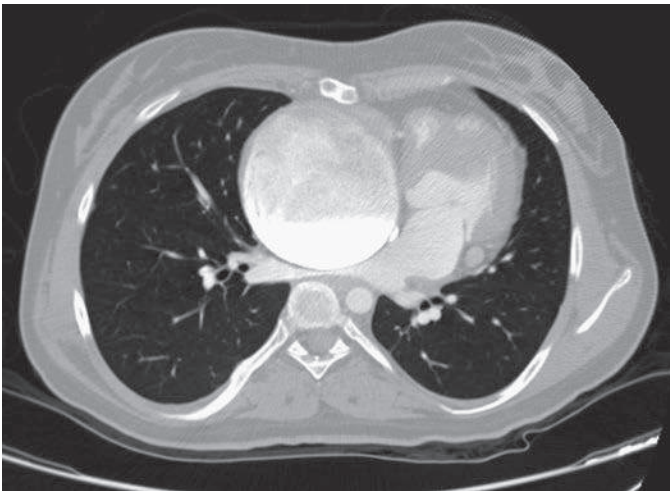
Computed tomography scan of atriopulmonary Fontan showing the markedly enlarged right atrium compressing the right pulmonary veins. (Courtesy Joshua Robinson, MD.)
